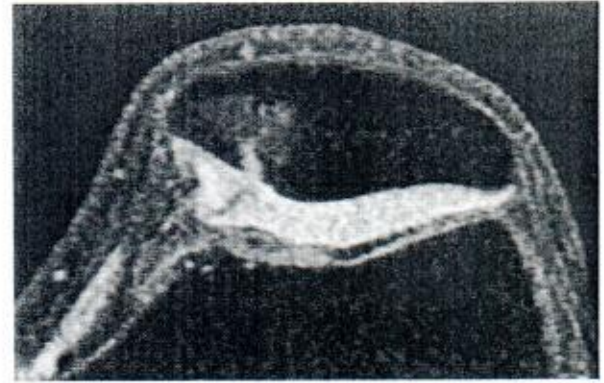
MR image of cartilage fissure and adjacent bone marrow lesions on a 3D SPGR/FLASH sequence. (Courtesy of J. Gelineck, MD, Aarhus, Denmark)
